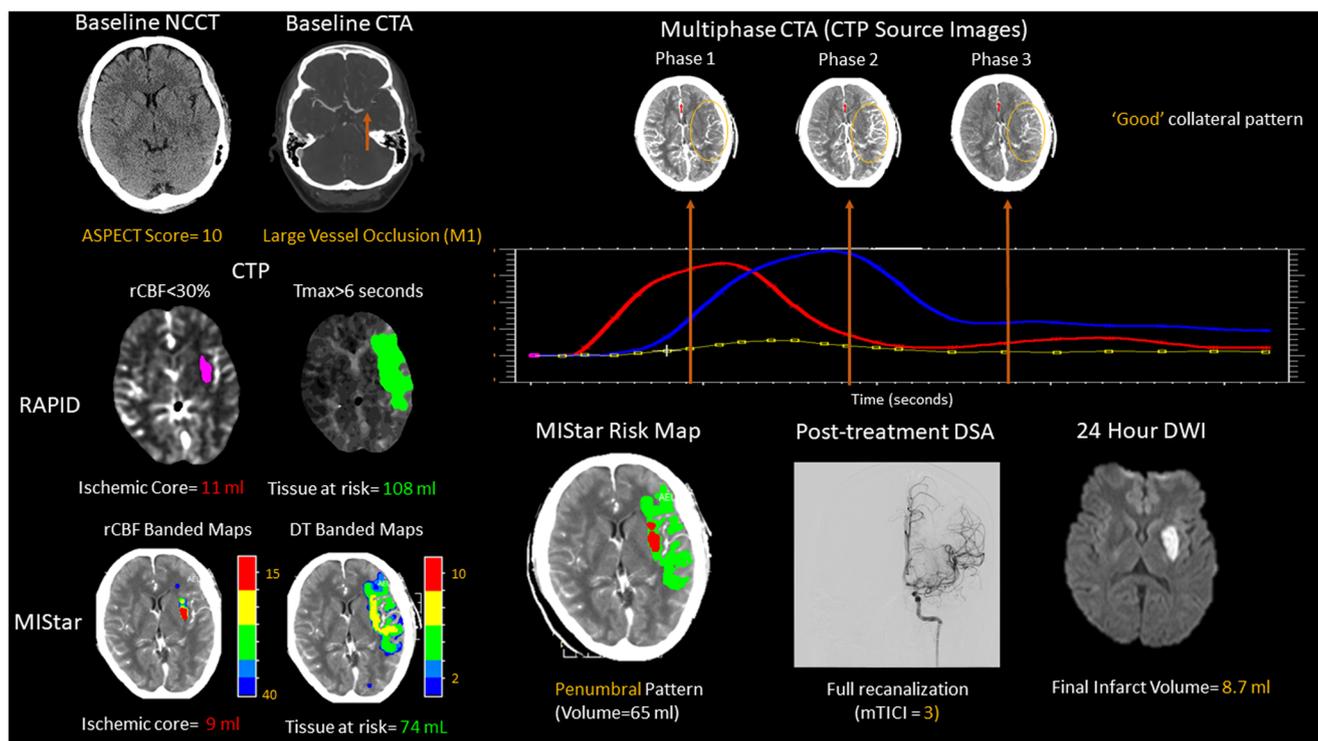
Multimodal CT obtained in a 74-year-old male at 7.5 h after stroke onset. The NCCT shows no evidence of parenchymal early ischemic change (Alberta Stroke Program Early CT Score, ASPECTS = 10). Occlusion of the M1 segment of the left middle-cerebral artery (MCA) is demonstrated on the CT Angiogram (CTA). Multiphase CTA obtained from CTP source images suggests good collateral flow, although delayed late phase washout has been associated with poor outcome (see text). CT perfusion (CTP) images were post-processed using both the MISStar and RAPID software. Both programs utilize a double threshold approach to
